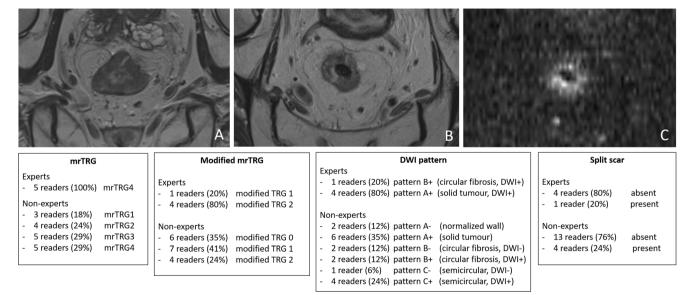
Impact of reader experience. Pre-treatment axial T2-weighted (A) and post-CRT axial T2-weighted (B) and DWI (C) images of a male patient with a scan graded as good quality. On pre-treatment MRI, a circular tumor lesion is seen. Post-CRT, predominant tumor signal remains with a persistent high signal on DWI. As detailed in the boxes
